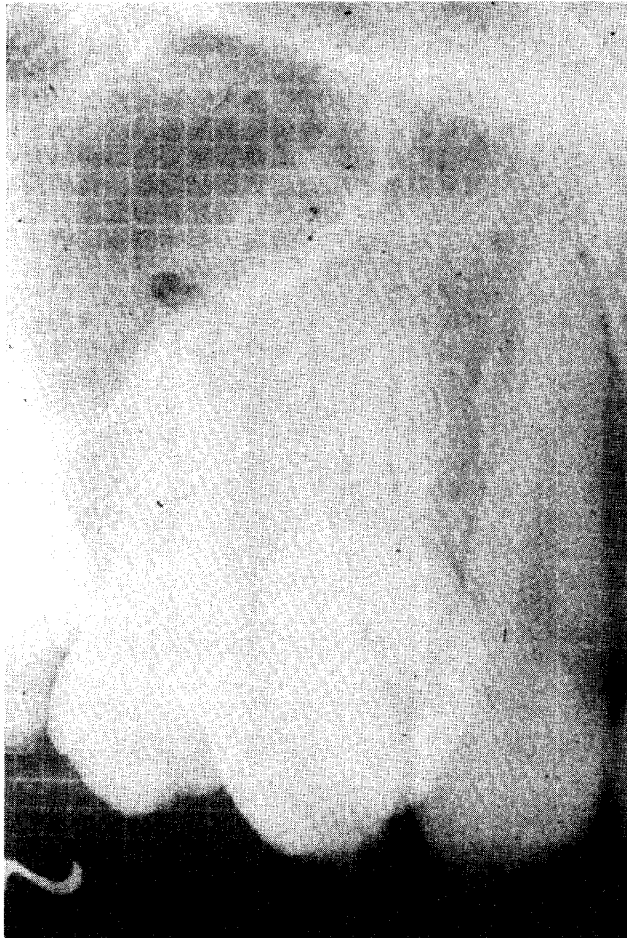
Periapical Radiograph of Cuspid and Supernumerary Cuspid.
